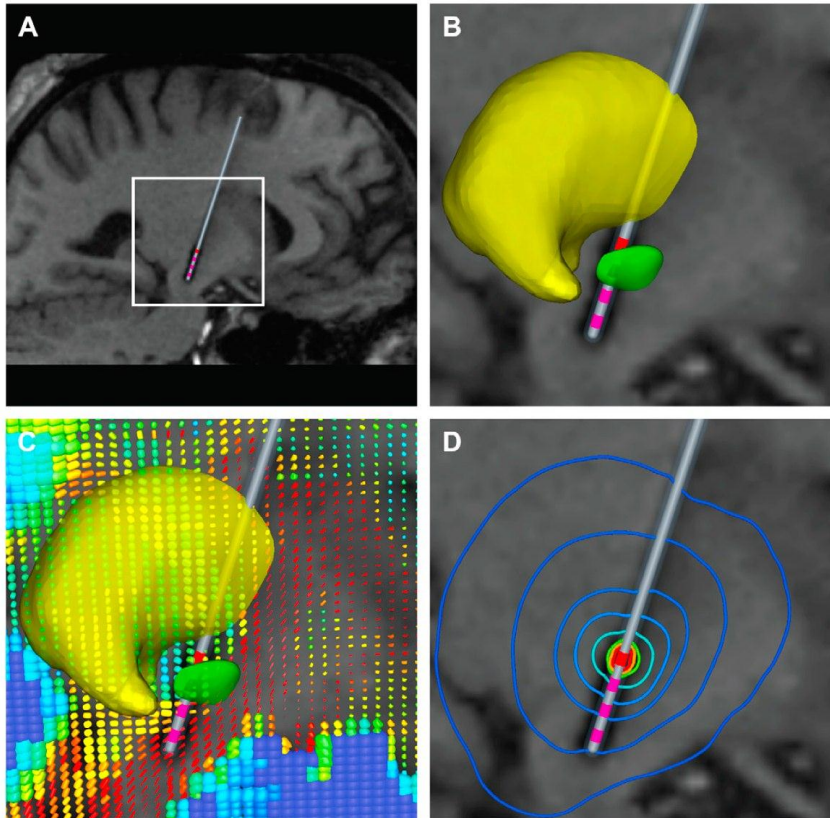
‘Patient-specific DBS model. (A) Sagittal view of the post-operative patient MRI with the patient-specific electrode location and trajectory determined by image-thresholding segmentation. Also shown is a white bounding box depicting the region of interest for panels B-F. (B) 3D nuclei placed within the same patient-specific modeling environment (thalamus – yellow volume; STN – green volume). (C) DTI tensors displayed as ellipsoids. The colors depict the individual fractional anisotropy values of the tensors (blue-0; red-1), while the shape describes both the magnitude and direction of water diffusion (spherical – isotropic; cylindrical – anisotropic). (D) Isolines depicting the potential distribution near the active contact 3 (blue – low voltage; red – high voltage) (Chaturvedi et al. 68).’
